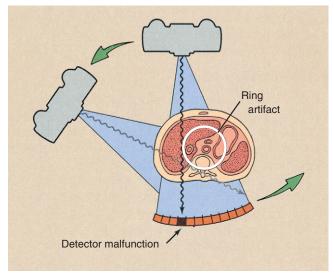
Ring artifacts can occur in third-generation computed tomography imaging systems because each detector views an annulus (ring) of anatomy during the examination. The malfunction of a single detector can result in the ring artifact.
